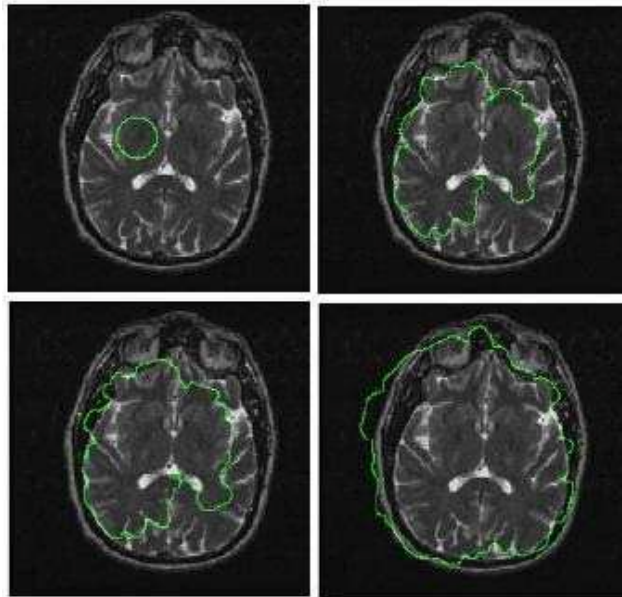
Difficulty of using the CasellesMalladi deformable contour in segmenting the brain in T2-weighted MR images. (a) The initial contour that was not symmetrically placed. (b) The contour was confined inside the brain by the inner high intensity structures using a strong stopping force. (c) Some of the contours were crossed over the brain boundaries while some contours were restricted inside, using a slightly weaker stopping force. (d) The contour leaked past the brain boundaries using a weaker stopping force [Chang 2008].
